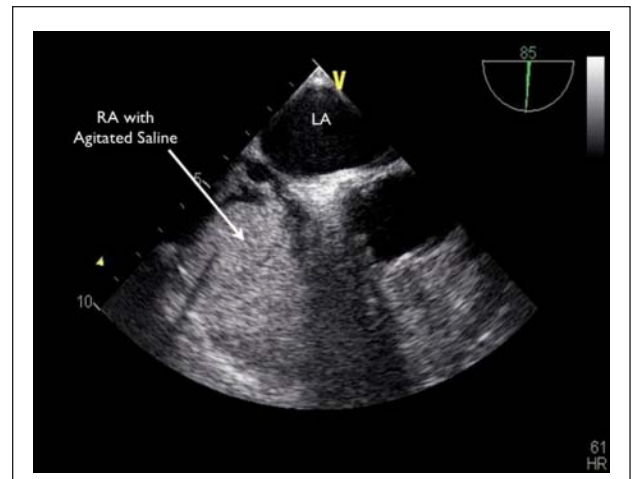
Transesophageal echocardiography mid-esophageal view showing opacification of the right heart by injection of agitated air-saline contrast
